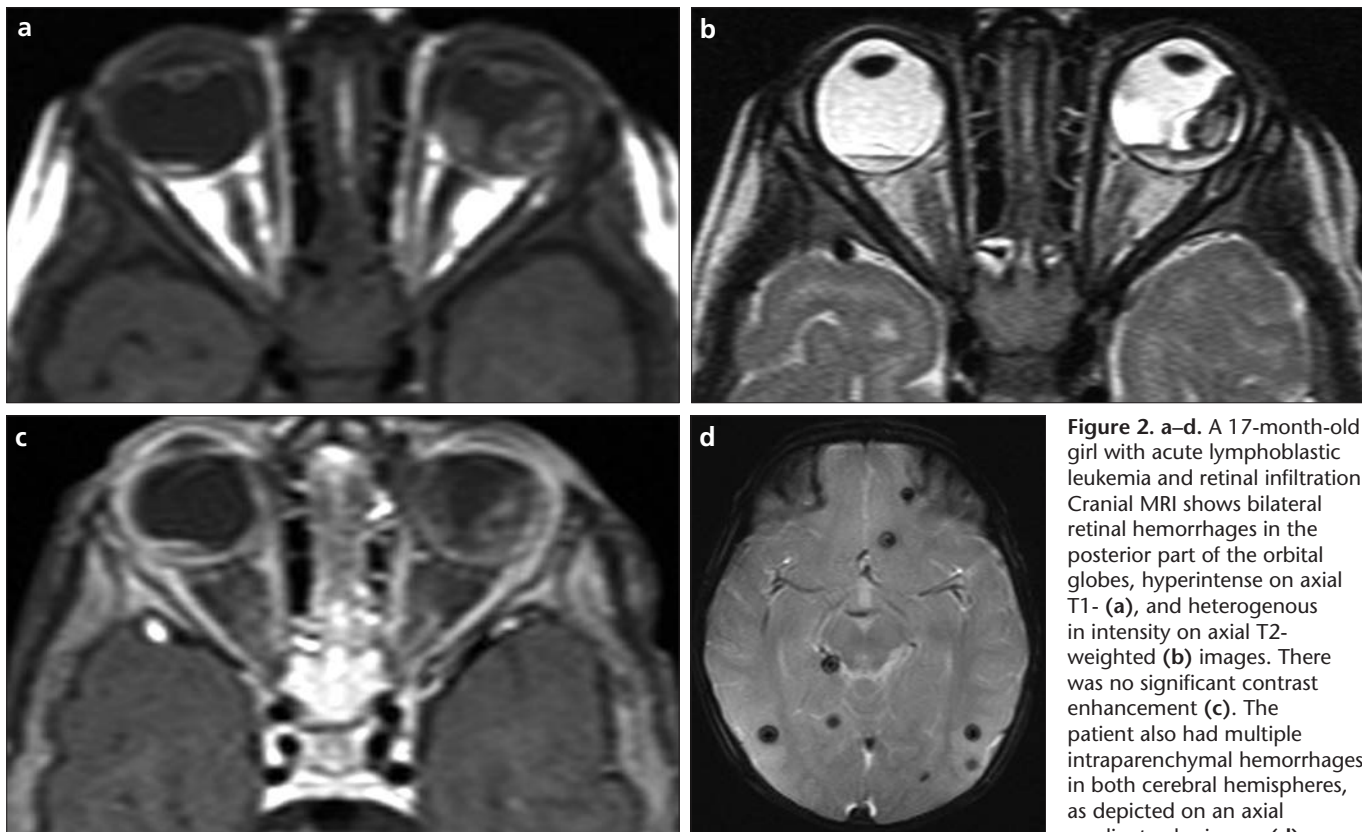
a–d. A 17-month-old girl with acute lymphoblastic leukemia and retinal infiltration. Cranial MRI shows bilateral retinal hemorrhages in the posterior part of the orbital globes, hyperintense on axial T1- (a), and heterogenous in intensity on axial T2-weighted (b) images. There was no significant contrast enhancement (c). The patient also had multiple intraparenchymal hemorrhages in both cerebral hemispheres, as depicted on an axial gradient echo image (d).
